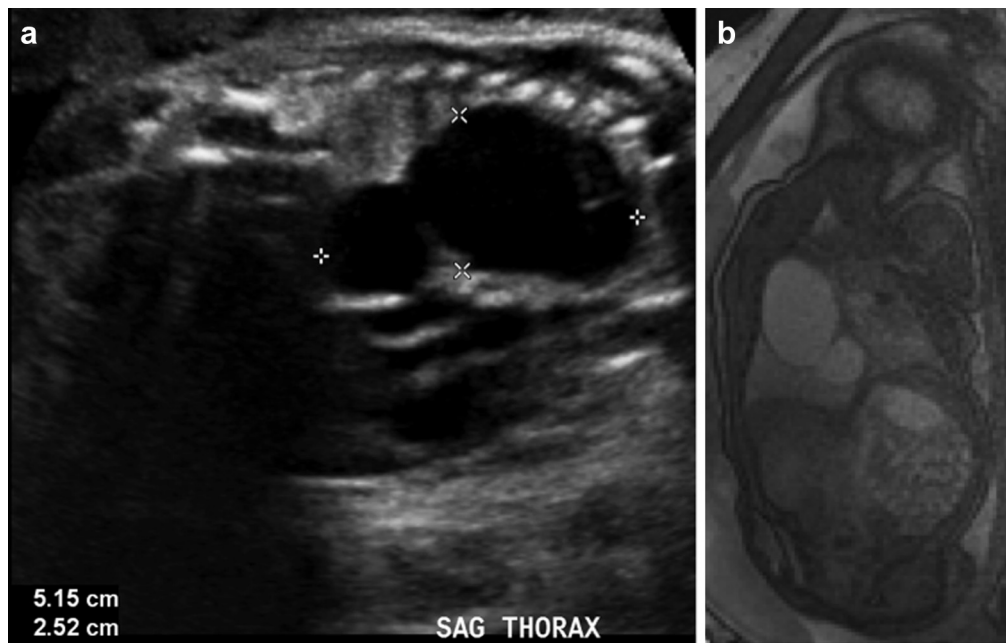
(a) Prenatal ultrasound demonstrates a bilobed anechoic 5.2×2.5 cm mass in the right hemithorax. (b) Coronal fetal MRI demonstrates a bilobed mass in the right hemithorax similar to that seen on the fetal ultrasound.
